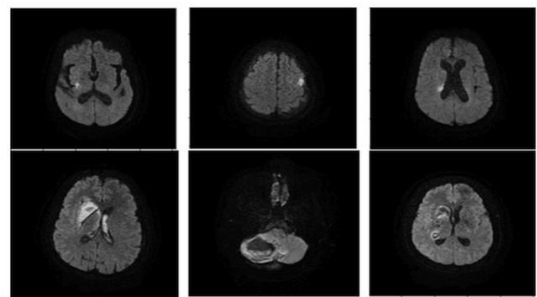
Samples of stroke types in DWI, SWI MR images
